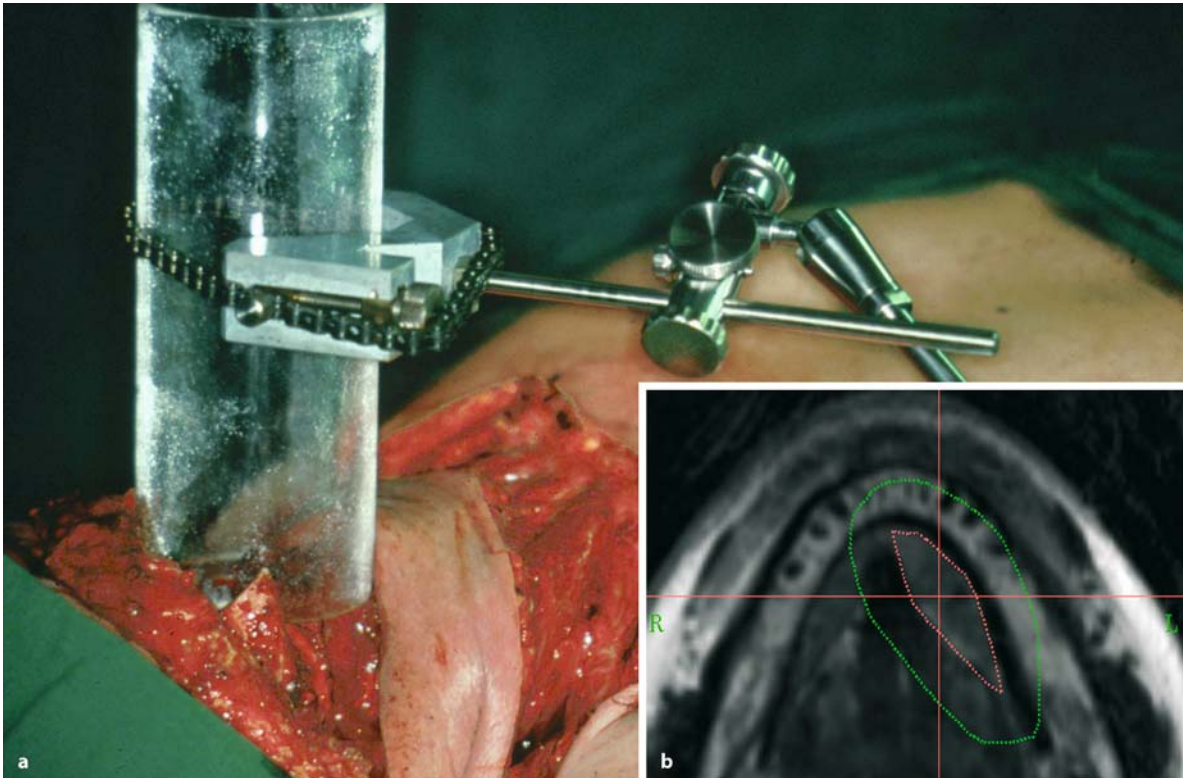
Navigation-assisted alignment of the X-ray tube for intraoperative radiotherapy. a The resection of a malignant tumor is followed by the pointer-based alignment of the X-ray
